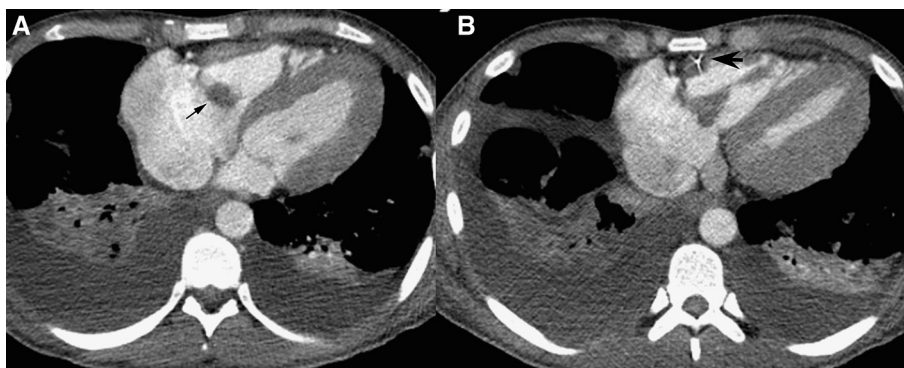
Valvular vegetations. Contrast-enhanced axial computed tomography images, (A) showing a lobular soft-tissue mass adherent to the tricuspid valve (thin black arrow) in a patient with a history of intravenous drug use. (B) The metallic artifact (thick black arrow) in the tricuspid valve apparatus was subsequently confirmed to be a retained needle.
